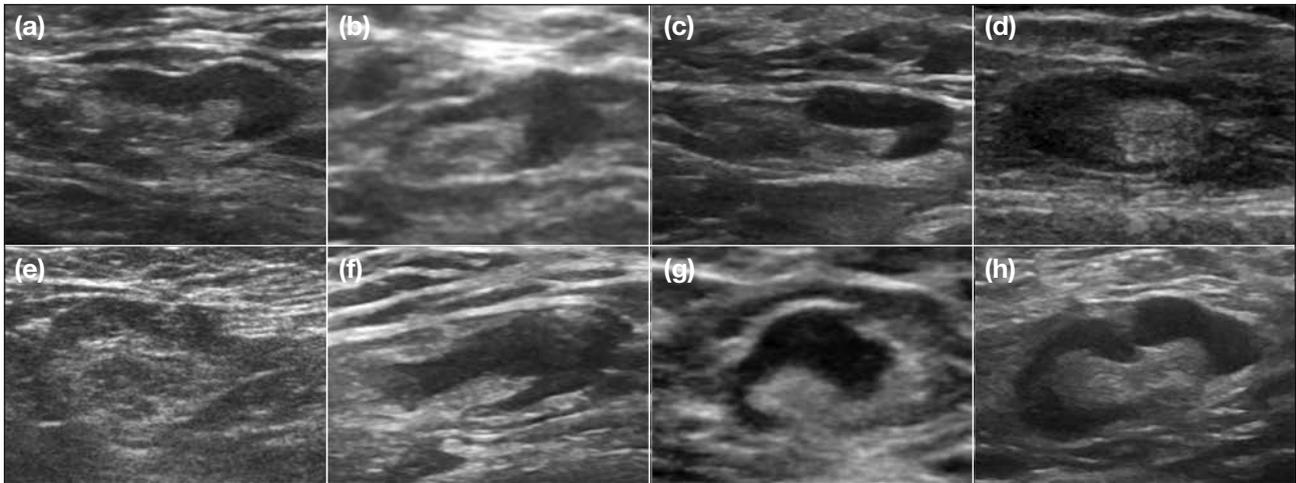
Ultrasound images of selected lymph nodes in the intermediate suspicion group (Group 2), which were those with diffuse uniform cortical thickening (≥ 3 mm) and a preserved central echogenic hilum. There might be minor surface lobulations or lobulations which follow the contour of central hilum.
